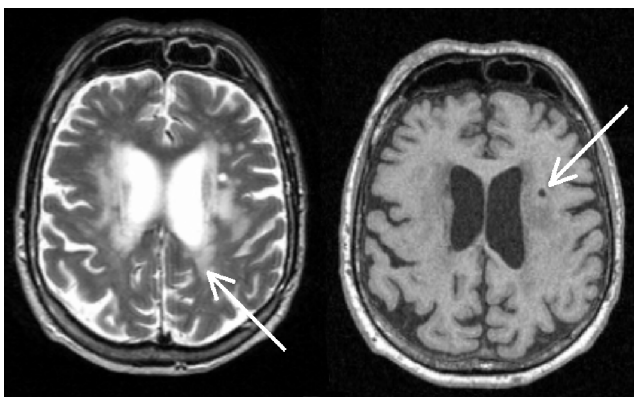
T2-weighted (on the left) and T1-weighted (on the right) MRI exams of the same subject at 75 years old. This subject has a severe grade of WMH (arrow), mainly in the periventricular area, easily seen on the T2 exam (left). He also has a silent infarct (arrow) in the white matter which appears in hypointensity on the T1-weighted exam (right)
